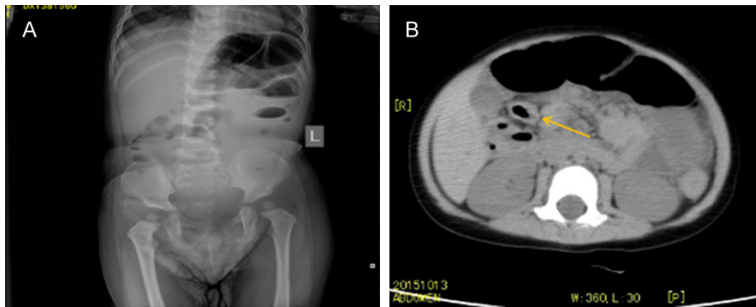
Preoperative radiological findings. A. X-ray of the abdomen (sagittal plane) showed distension of the small bowel with air-fluid levels and no free air. B. Computed tomography scan of the abdomen showed extreme distension of the colon and edema of the intestinal wall (arrow).
